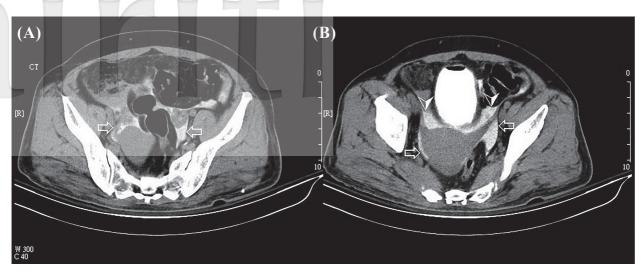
Abdominal computed tomogram cystogram revealed accumulation of contrast medium at the intramesenteic space (arrows) (A), the cul-de-sac (arrows) (B), and the paravesical space (arrow heads) (B).
